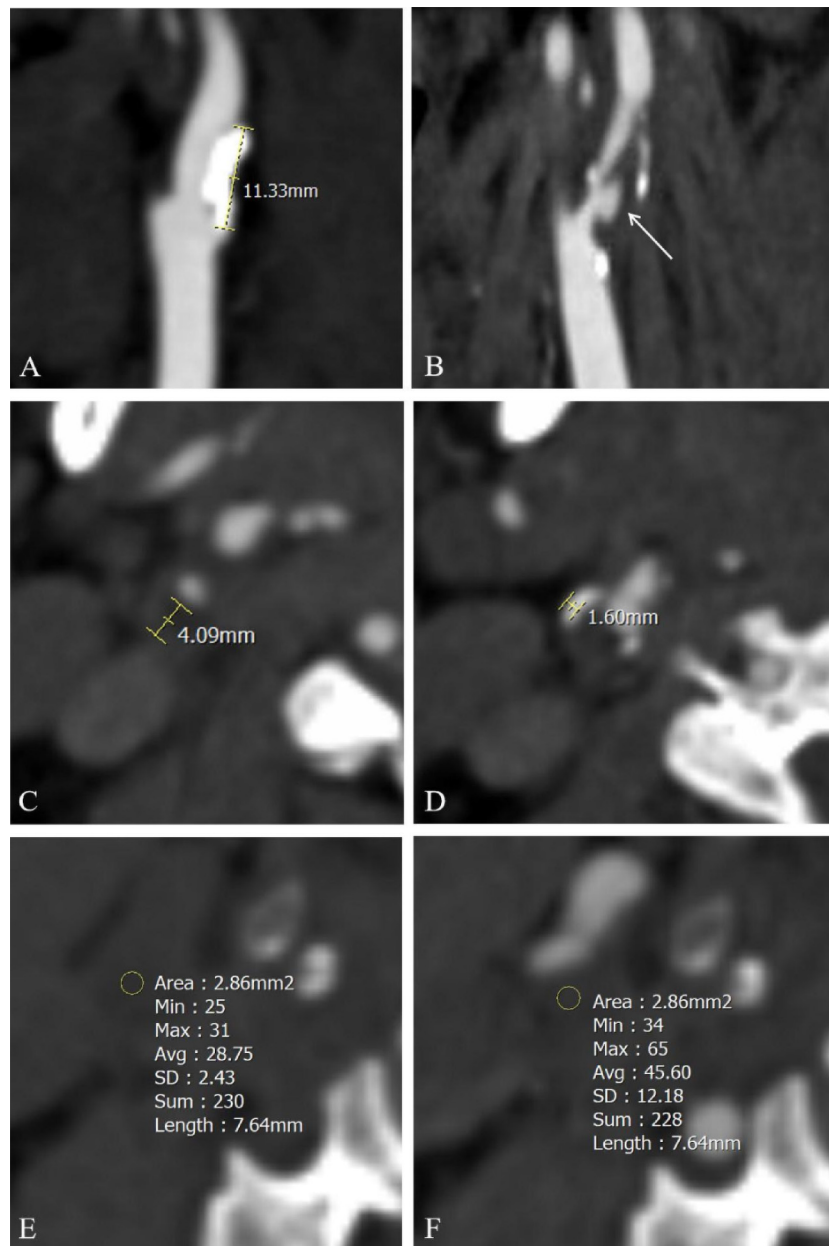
Display and measurement of CTA plaque features. (A) Calcified plaque of the internal carotid artery and plaque length measurement. (B) Plaque ulceration (arrow). (C) Total plaque thickness and soft plaque thickness (on the same level, both values are equal). (D) Calcified plaque thickness at a different level from C. (E and F) Plaque enhancement (image before and after contrast injection). CTA, computed tomography angiography.
